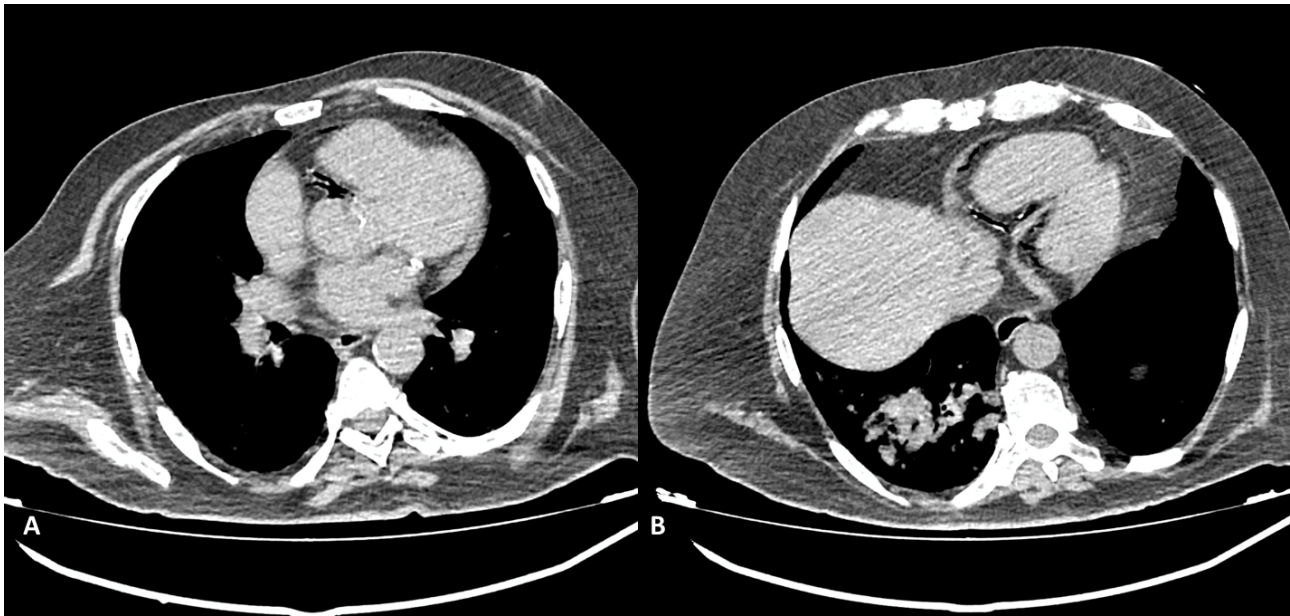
Non contrast-gated CT, axial planes: air presence in the RCA and its branches can be noted. Scan was performed in the immediate follow-up after a CT-guided lung biopsy procedure, in a symptomatic (chest pain and dispnea) patient.
